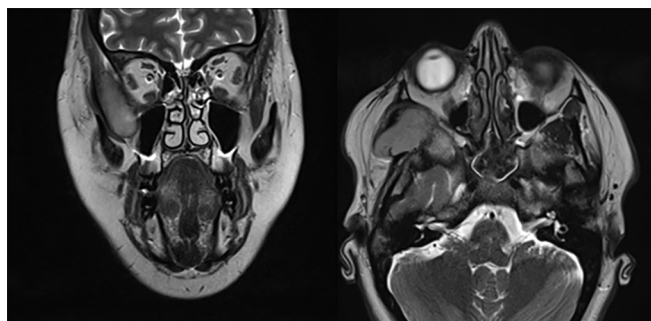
Coronal and axial T2-weighted MR images depicting a lobulated 3.7 × 3.4 × 1.5 cm synovial sarcoma in the right temporalis region causing remodeling of the posterolateral orbital wall. This 42 year old woman's sarcoma was detected due to the socially sensitive location of the tumor leading to recognition of a non-resolving lump. She was successfully treated with pre-operative radiotherapy, 50 Gy in 25 fractions, followed by surgical resection.
